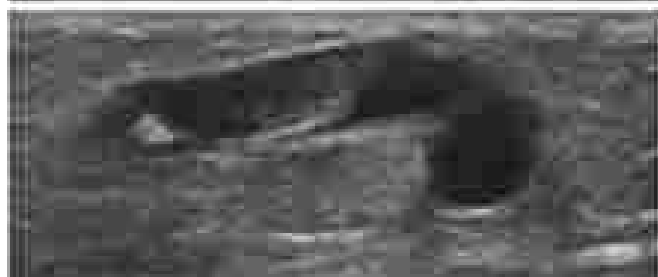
Ultrasound-guided injection of physician-compounded foam. The foam can be seen to gradually fill and span the treated vein.
